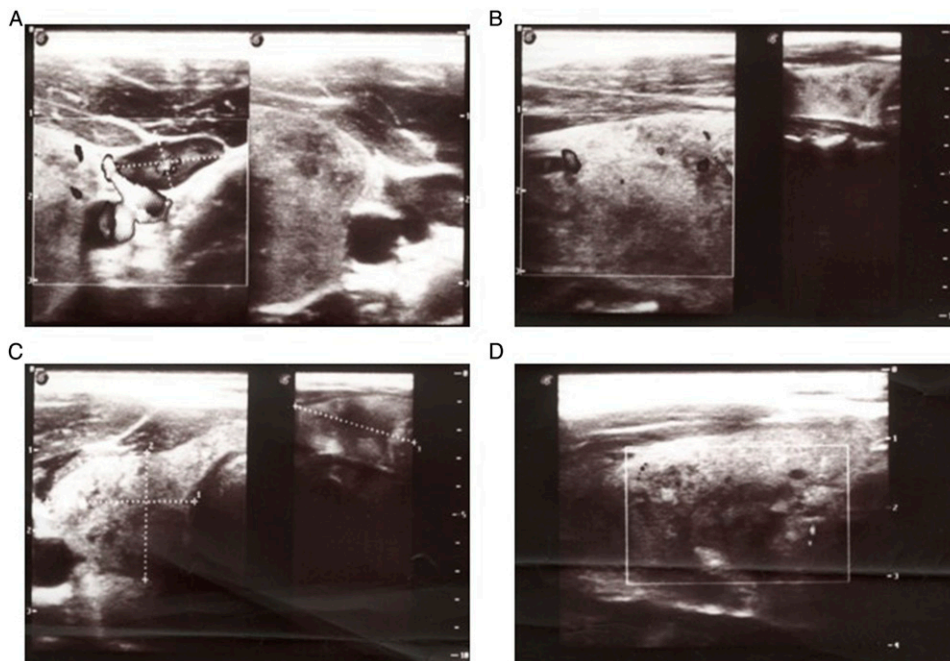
The thyroid gland's left lobe in (a) transverse (left side: an enlarged reactive lymph node near the thyroid's left lobe) and (b) longitudinal scans. The thyroid gland's right lobe in (c) transverse and (d) longitudinal scans. Ultrasonography of the thyroid gland was performed on the Toshiba Xario SSA-660A device by linear probe 7.5 MHz.
